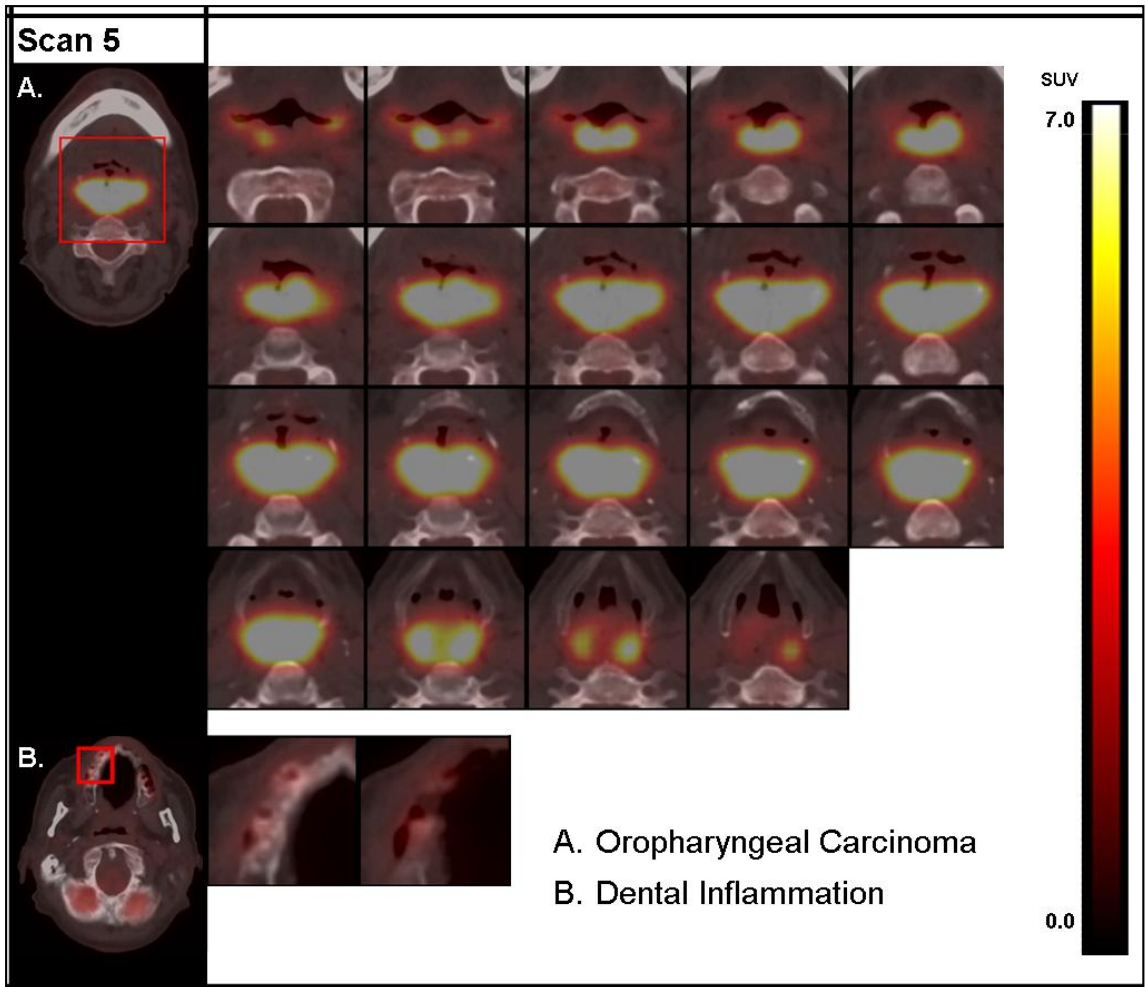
Figure Appendix A: Showing all the sections, along the craniocaudal axis, of all those VOIs which have considerable ^{18}F -FDG uptake and were included in the study.
